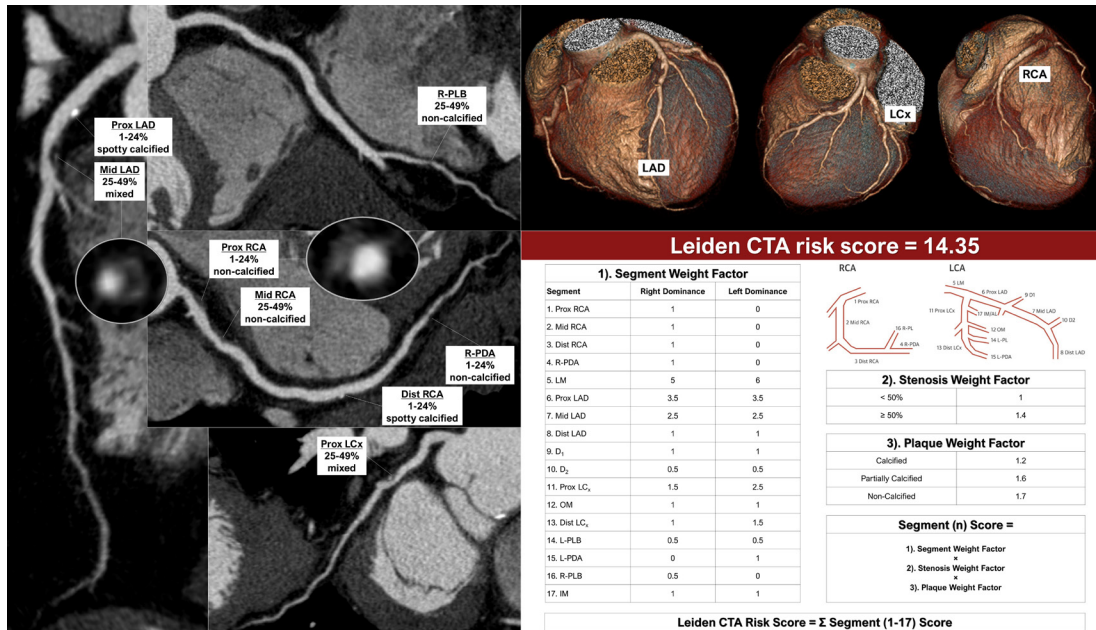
Leiden CTA risk score. An example of Leiden CTA risk score calculation. The new, comprehensive CTA score is calculated by addition of the individual segment scores, which are obtained by multiplication of the plaque weight factor, the stenosis weight factor, and the location weight factor. Leiden CTA risk score calculator is available at: <http://18.224.14.19/calcApp/>. CTA, CT angiography; R-PDA, right posterior descending artery; RCA, right coronary artery; LCA, left coronary artery; LAD, left anterior descending; LCx, left circumflex; R-PLB, right posterolateral branch.
